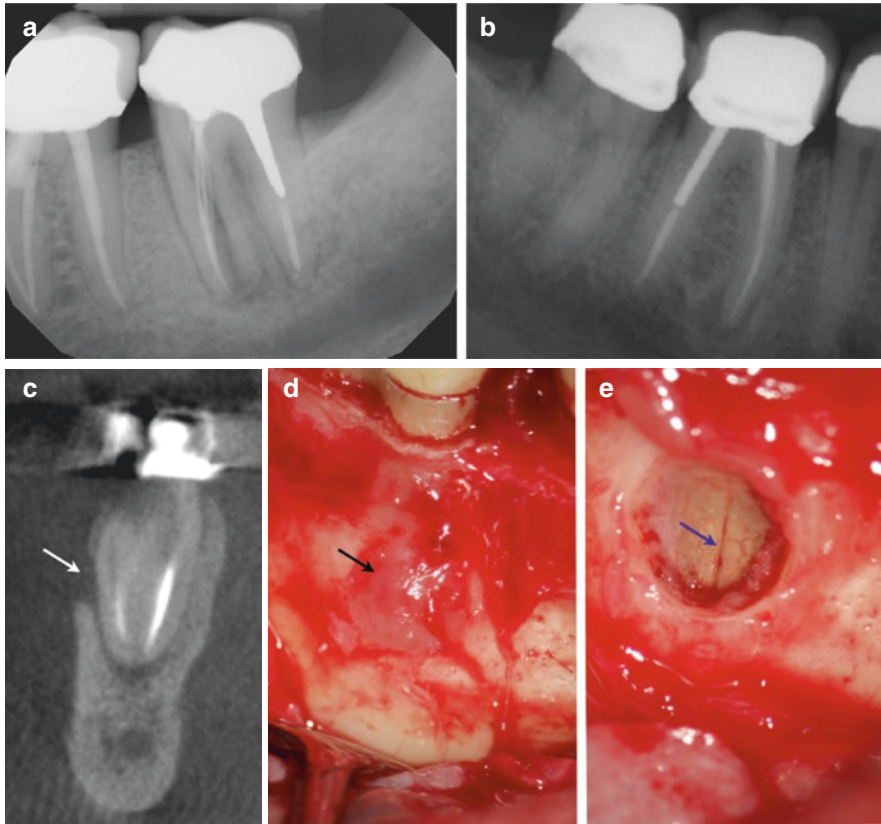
(a) Image demonstrating an obvious example of a vertical root fracture in the mesial root of previously treated tooth #18. In the early stages of incomplete root fracture, the appearance is not as obvious and can often present a diagnostic challenge. (b) Example of an endodontically treated #30 that developed a mid-root vertical fracture in the mesial root approximately 7 years after apparently adequate initial RCT. Although all periodontal probings were WNL, the coronal CBCT view of the mesial root shows a buccal bony dehiscence (c—white arrow). After surgical flap elevation, granulation tissue over the mid-root buccal surface of the mesial root was identified and curetted (d—black arrow). The vertical root fracture was then directly visualized (e—blue arrow). Extraction was the treatment option of choice for both of these teeth although it should be noted that hemisection would also have been an option (Reference [9], Fayad MI, Johnson BR, 2016)
